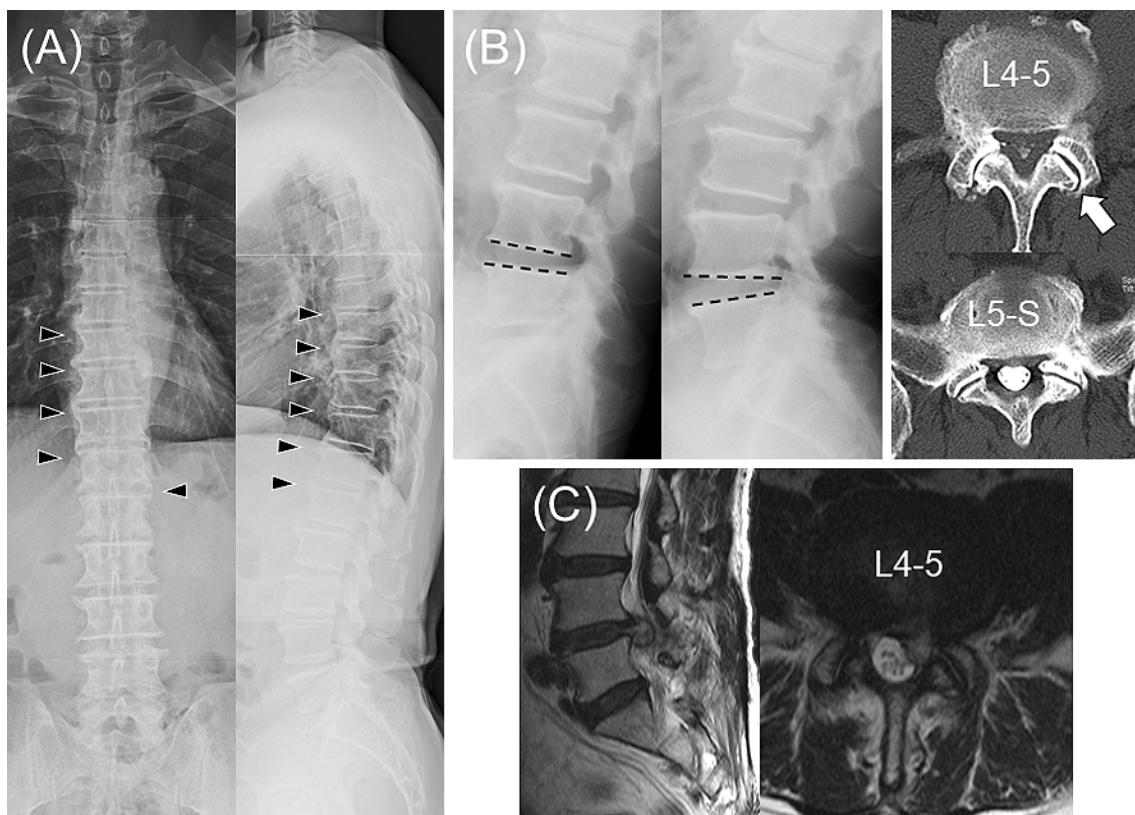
Representative case of a 71-year-old man. (A) Preoperative standing whole radiograph indicated diffuse idiopathic skeletal hyperostosis from T7 to L1 (triangle). (B) Left: Preoperative flexion and extension radiograph showed a 10° of sagittal rotation angle at L4-5. Right: preoperative computed tomography showed facet opening at L4-5. (C) Magnetic resonance imaging showed disc herniation at L4-5 1 year after L4-5 and L5-S decompression surgery, and the patient underwent revision decompression surgery at L4-5.
